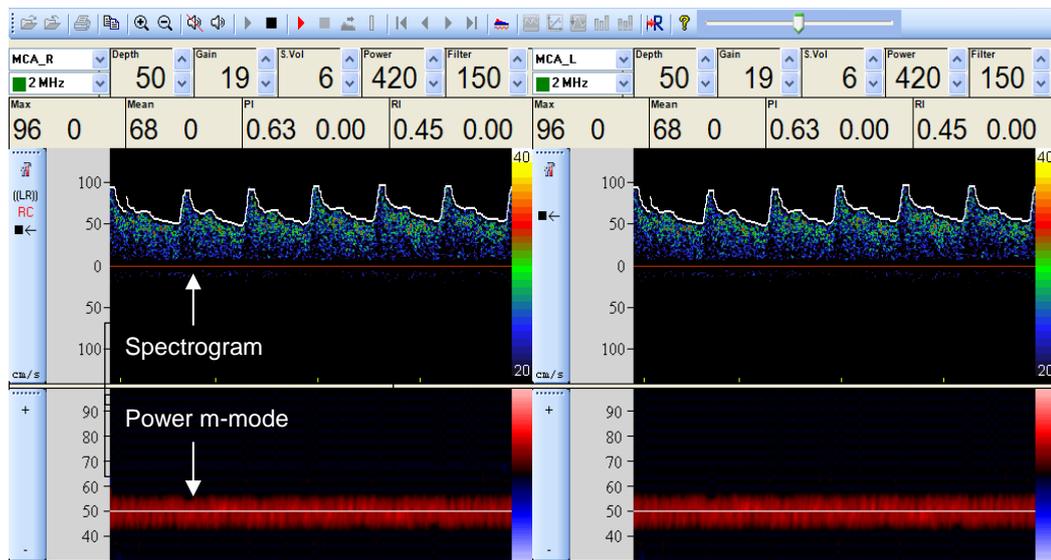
MCA Doppler spectrogram
